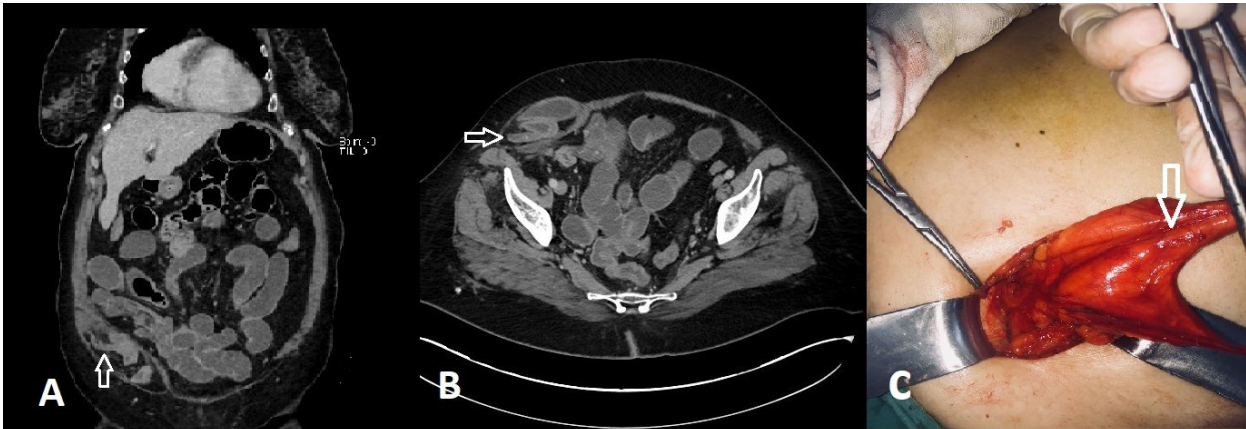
The coronal CT (A) and axial CT (B). The arrows indicate the insert within the SH sac. Peroperative appendix and mesoapandix (C). The marked arrow shows the appendix inside the opened hernia sac
